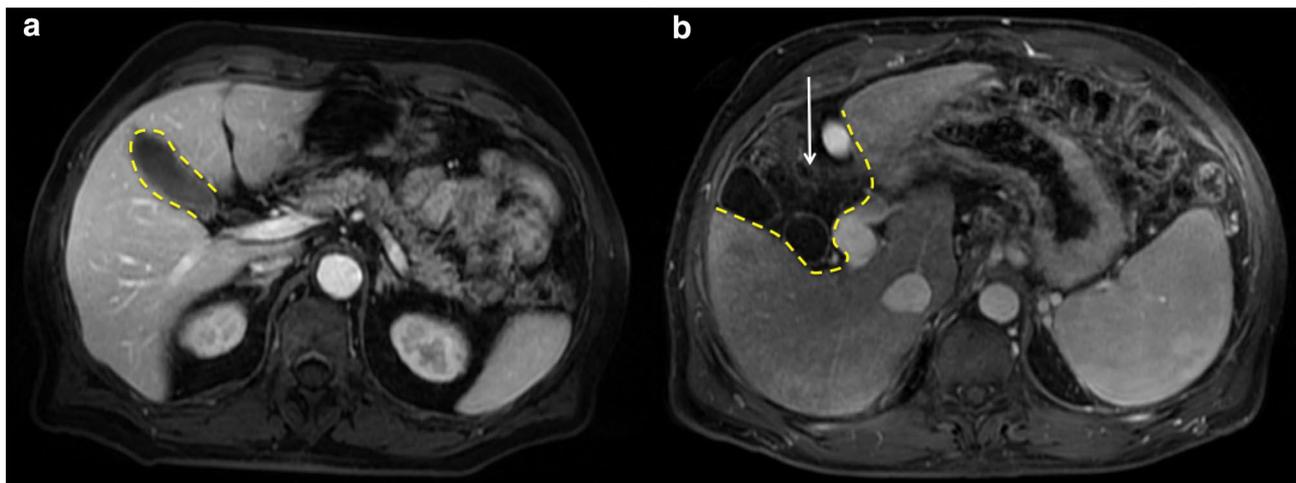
The normal gallbladder fossa (yellow line) containing minimal fatty tissue between the gallbladder and the liver in healthy patients, as shown in an axial, portal phase MR image (a). An axial MR image
